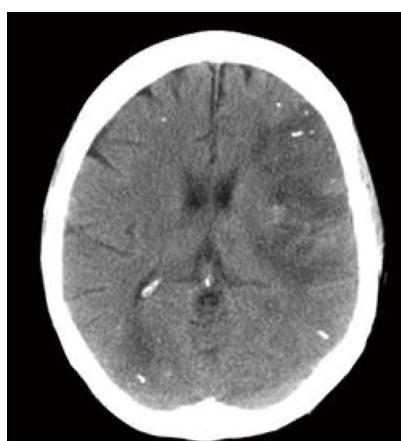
Computed tomogram of brain following glue/lipiodol injection. There are high signal deposits peripherally following embolisation of glue.
